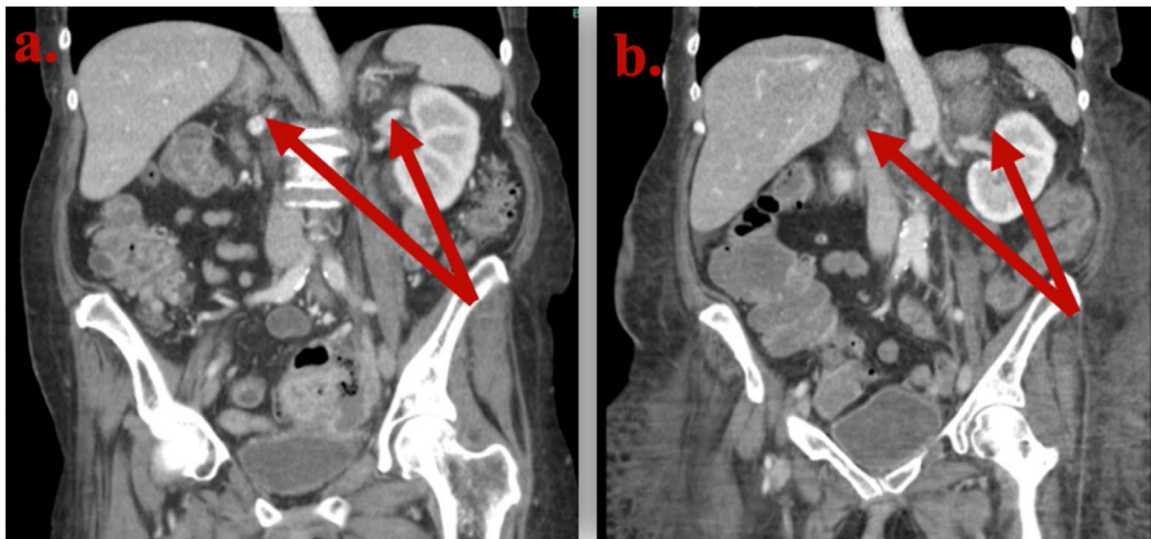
a. Preoperative CT scan with diagnosis of perforated diverticulitis. (Normal Adrenal Glands). b. Post-operative CT scan with diagnosis of Bilateral Adrenal gland hemorrhage.
